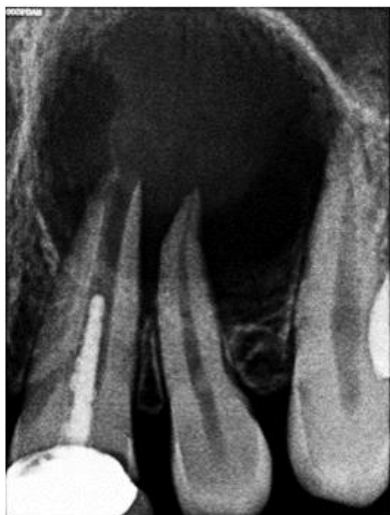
Pre – operative radiograph wrt 21,22
